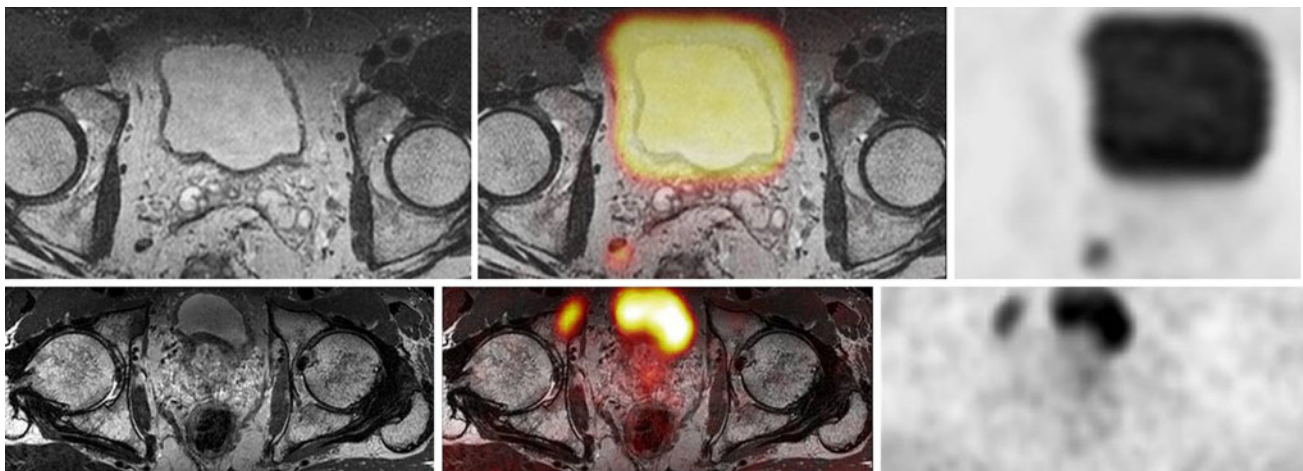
Example of correct and low quality fusion of PET and MRI images due to different bladder filling. In the upper row, PET data were acquired after the MRI data and bladder distension was more important on the PET images, resulting in an inaccurate fusion of both imaging modalities. As a result, the PET with 18F-Fluorocholine signal uptake of the abnormal lymph node just behind the right seminal gland is shifted posteriorly. This misregistration related to
